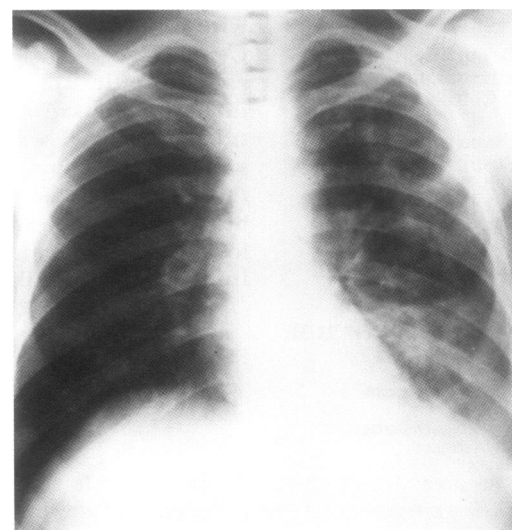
Chest radiograph of a patient with tuberculosis showing a left pleural effusion and left lower lobe involvement, features found less commonly in *M kansasii* infection than in tuberculosis.
